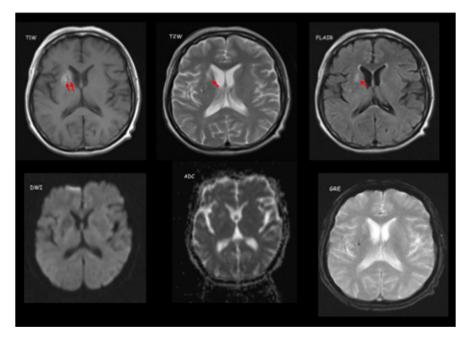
MRI: T1W, T2W/FLAIR images revealed hyperintense signals (red arrows) in the right internal capsule. No susceptibility artefact on GRE or area of restricted diffusion on diffusion imaging.
